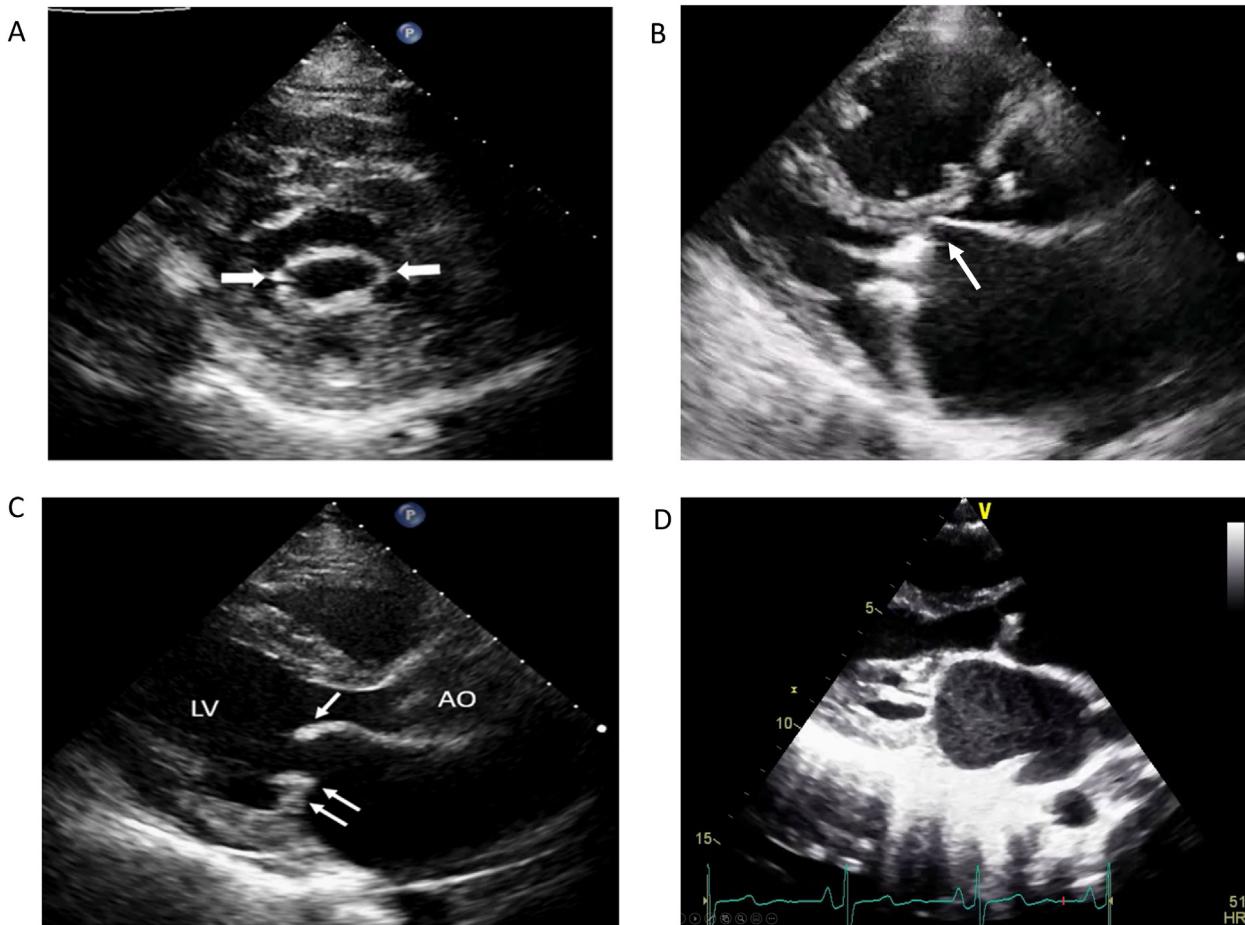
2D echocardiographic findings of MS. (A) Bi-commissural fusion (arrows) of a rheumatic valve in parasternal short-axis view. (B) Thickened and calcified mitral valve leaflets seen in parasternal long-axis view, with diastolic doming of the anterior leaflet (arrow). (C) Thickened and doming mitral anterior leaflet (single white arrow) and restricted motion of posterior leaflet (double arrows) in parasternal long-axis view. (D) Chordal thickening and calcification seen in parasternal long-axis view.
